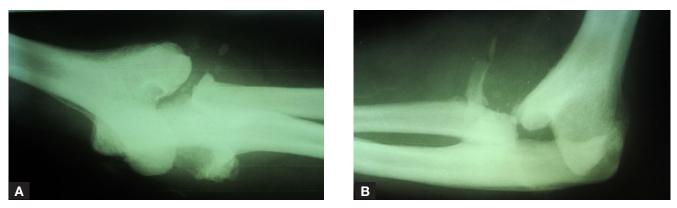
Case 1 – plain anteroposterior (A) and lateral (B) radiographs of right elbow show "5D": debris, increased density (sclerosis), destruction, disorganization, and dislocation.
